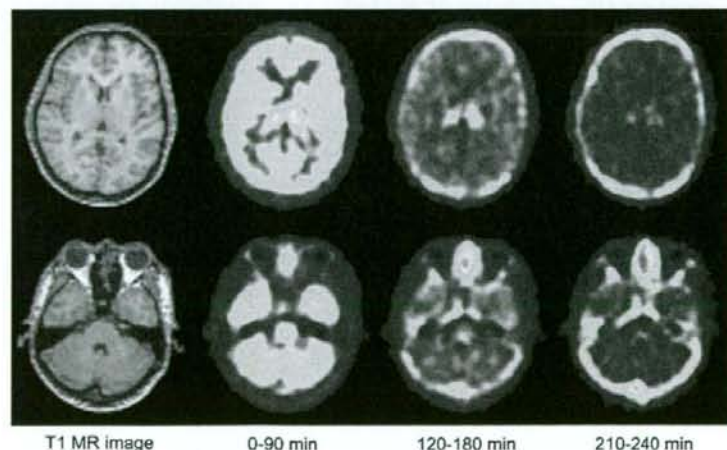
Typical summed PET images of (S,S)-¹⁸F-FMeNER-D₂ and T1-weighted MR images. Upper panel shows slice of caudate and thalamus, and lower panel shows slice of locus coeruleus.
